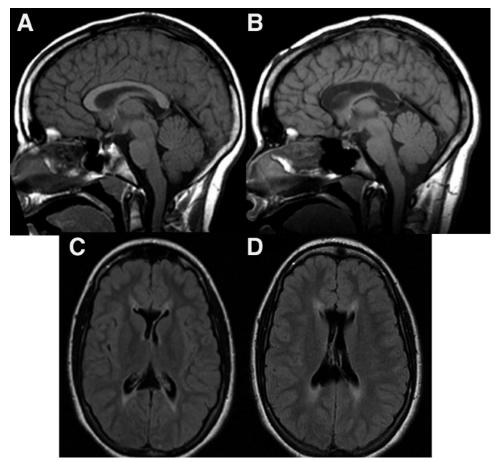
Magnetic resonance images. a: Sagittal T1-weighted image showing the intact corpus callosum (a). Sagittal T1-weighted (b) and axial FLAIR (c and d) images postcallosotomy demonstrating complete absence of the corpus callosum.
